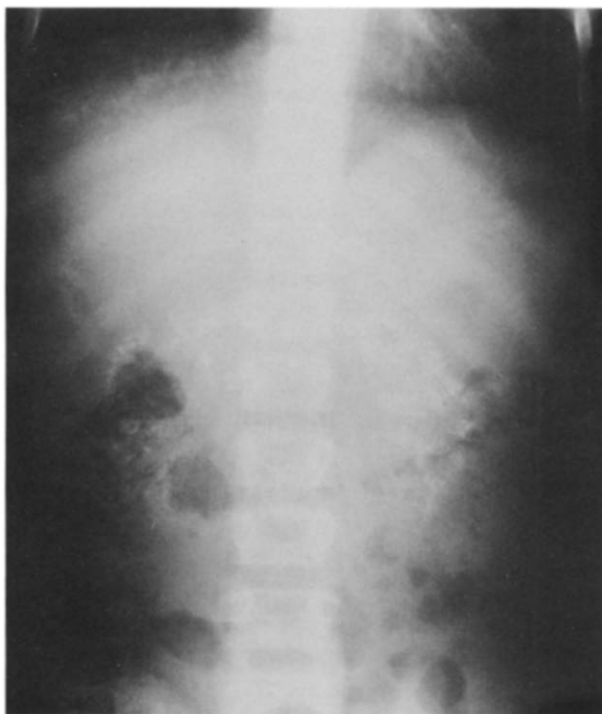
Abdominal x-ray of patient K.B. demonstrating diffuse bilateral nephrocalcinosis. Findings in the younger sibling, E.B., were similar.
